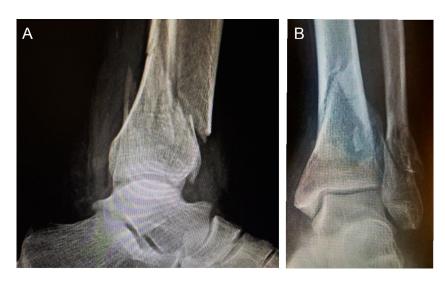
(A,B) Plain film radiographs demonstrating displaced distal tibial and fibular fracture.
